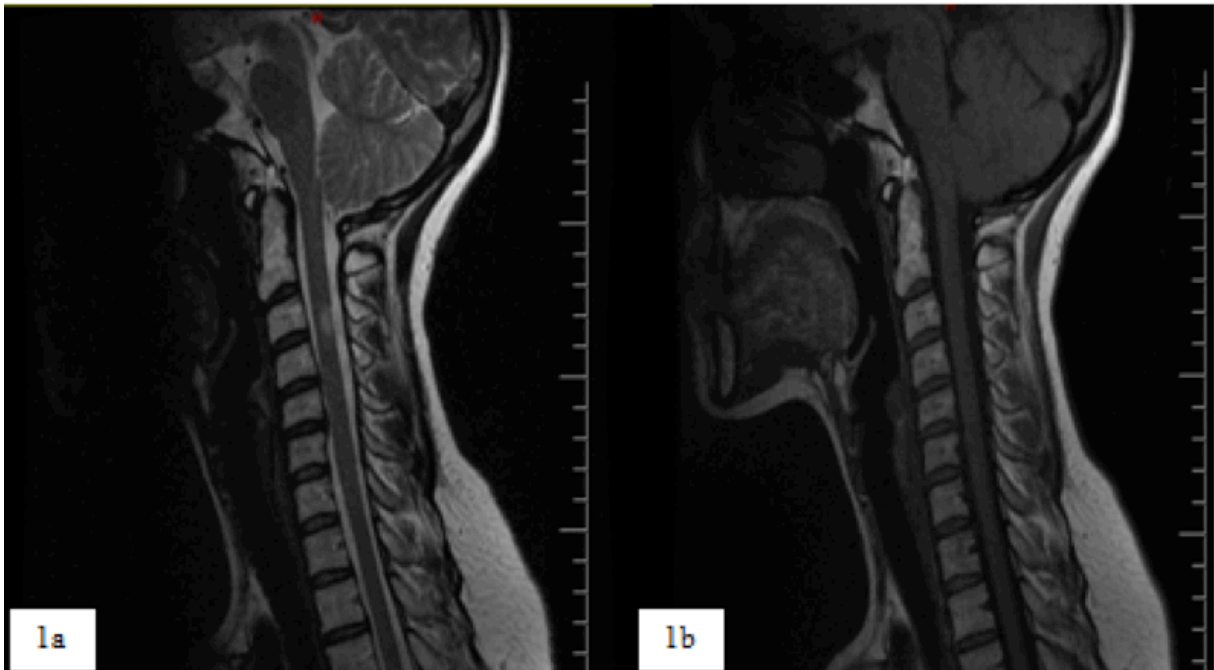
Lesion was detected as hyperintense on T1 images (1a) and isointense on T2 images (1b) on MRI scans
